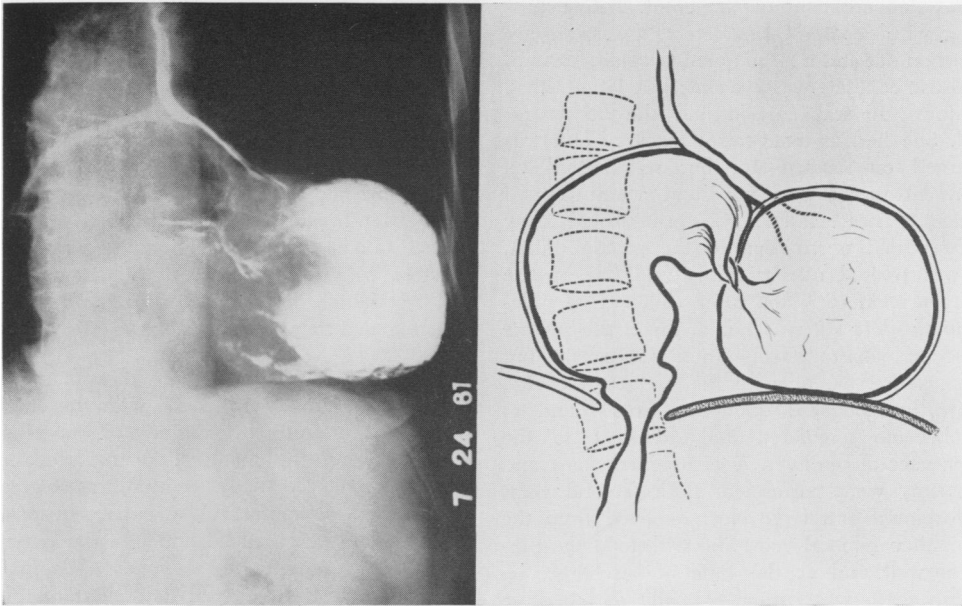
(Case 4). The only case in the present series of acute obstruction within a sliding hiatal hernia. X-ray demonstrates torsion at the mid portion of the stomach.
